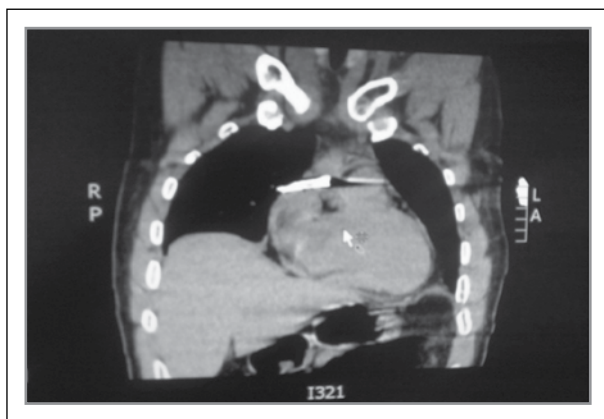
CT scan of the chest with IV contrast of a patient with gunnail in the right atrium
